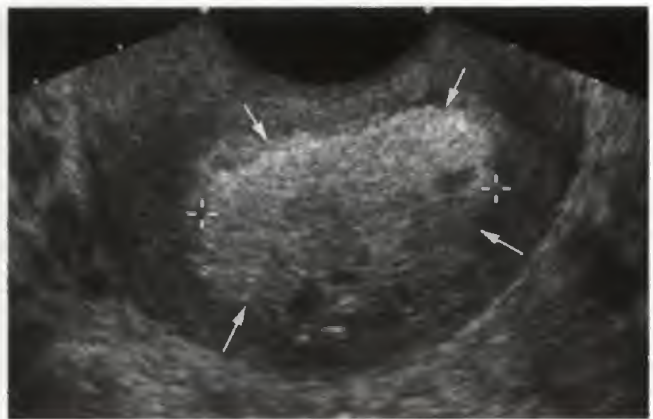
A. A patient presented with bleeding 1 week postpartum. Tissue (arrows) was seen within the endometrial cavity. B. Doppler imaging demonstrated no evidence of blood flow within the tissue (arrows). This represented blood clots without retained products of conception.
